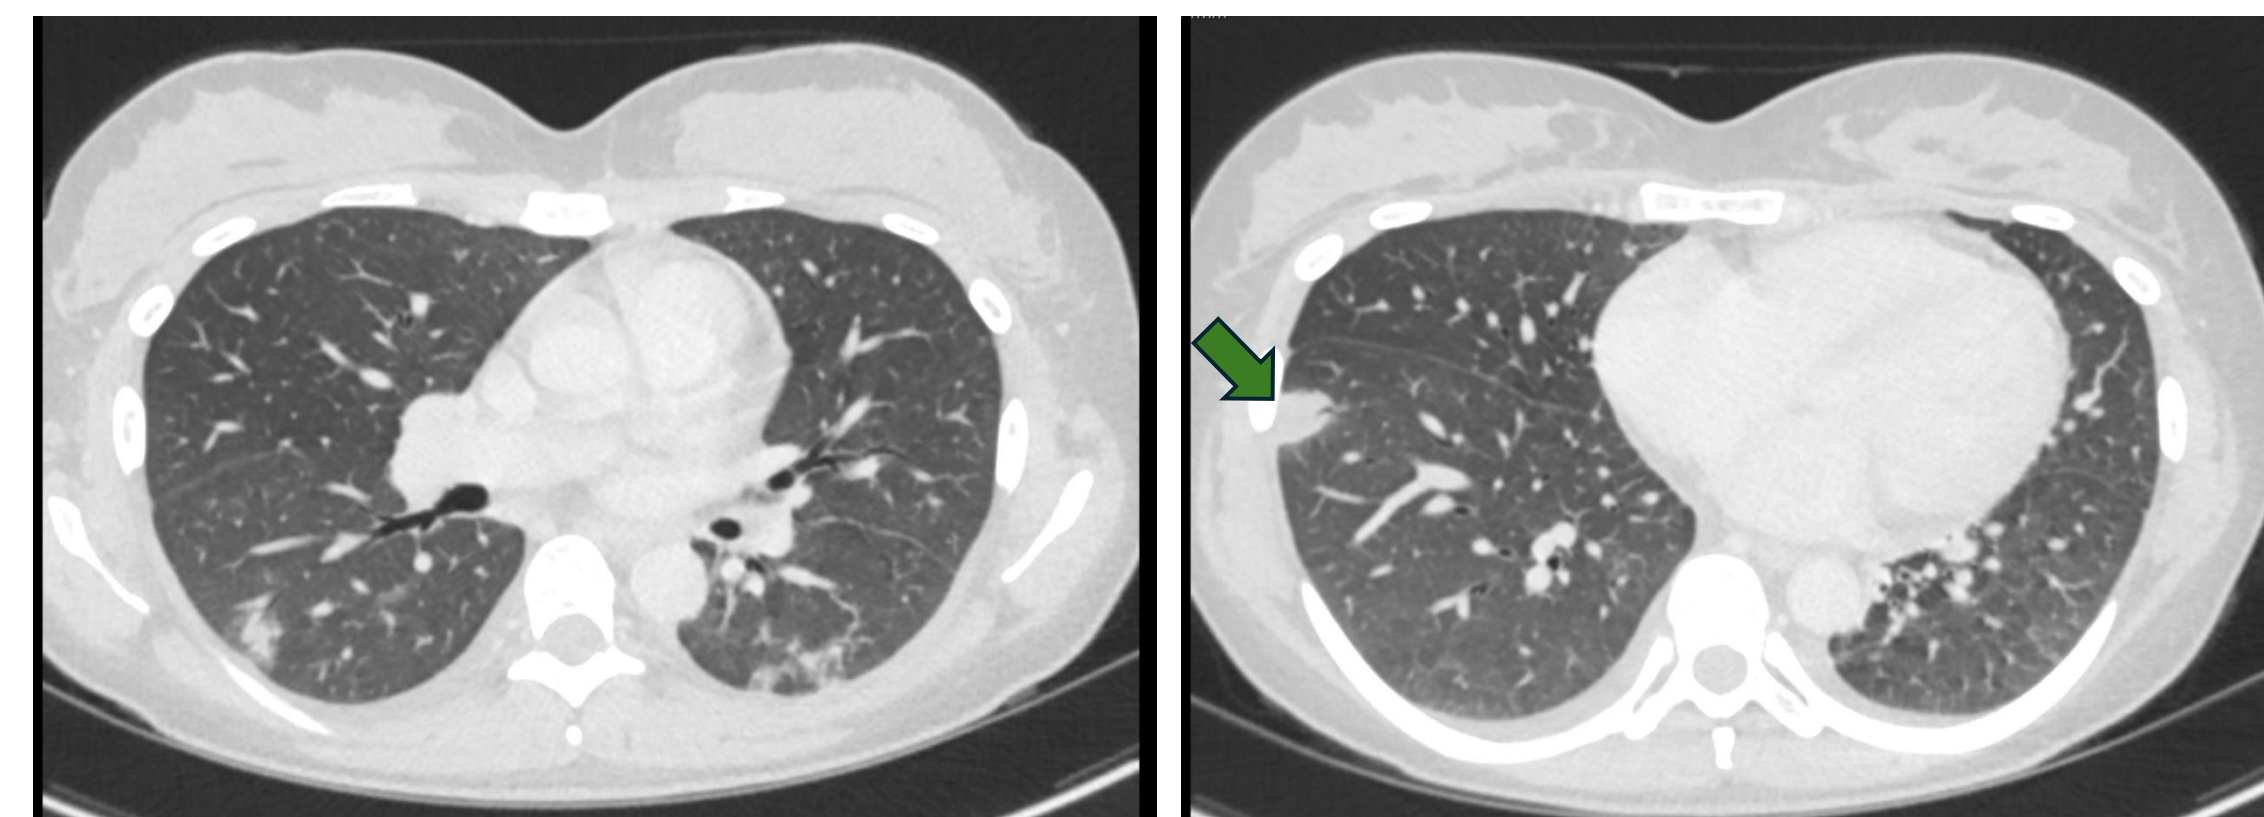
Axial view contrast-enhanced CT thorax
